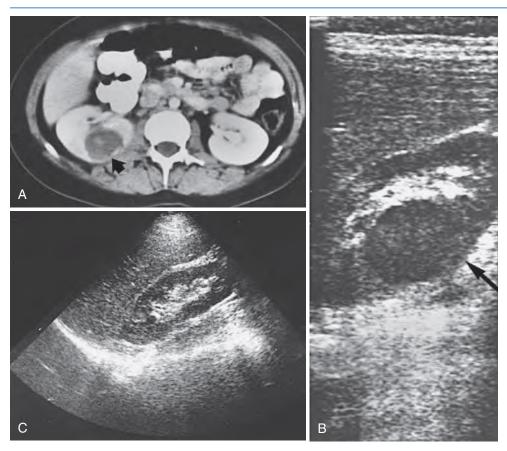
Acute pyelonephritis with a masslike lesion. (A) On a computed tomography scan, acute pyelonephritis with a (B) ultrasound examination of the right kidney shows the same masslike lesion (arrow). (C) The mass has resolved on the follow-up ultrasound study performed 2 months later. (Courtesy Dr. T. Slovis.)
